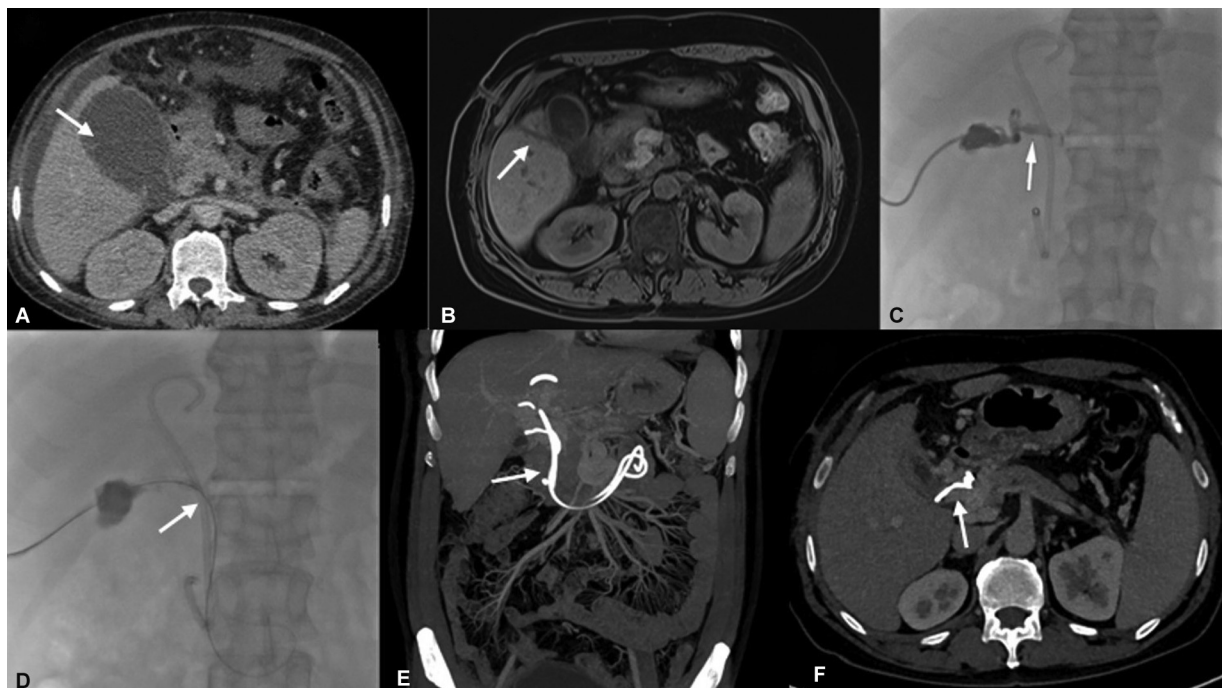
(A) Axial contrast-enhanced computed tomography (CECT) at initial presentation shows an overdistended gallbladder with marked mural thinning at places (arrows), suggesting the possibility of acute gangrenous cholecystitis. (B) Postcontrast axial T1-weighted magnetic resonance imaging shows partially decompressed gallbladder with a catheter in situ. (C) Cholangiogram obtained via cholecystostomy catheter shows a patent cystic duct (arrow). (D) Fluoroscopy image shows the guidewire advanced through the cystic duct, common bile duct, and via transpapillary route into the duodenum. (E, F) Coronal reformatted and axial maximum intensity projection images show cholecystoduodenal stent in situ with the proximal tip in the gallbladder neck and distal tip in the duodenum. The gallbladder is decompressed.
